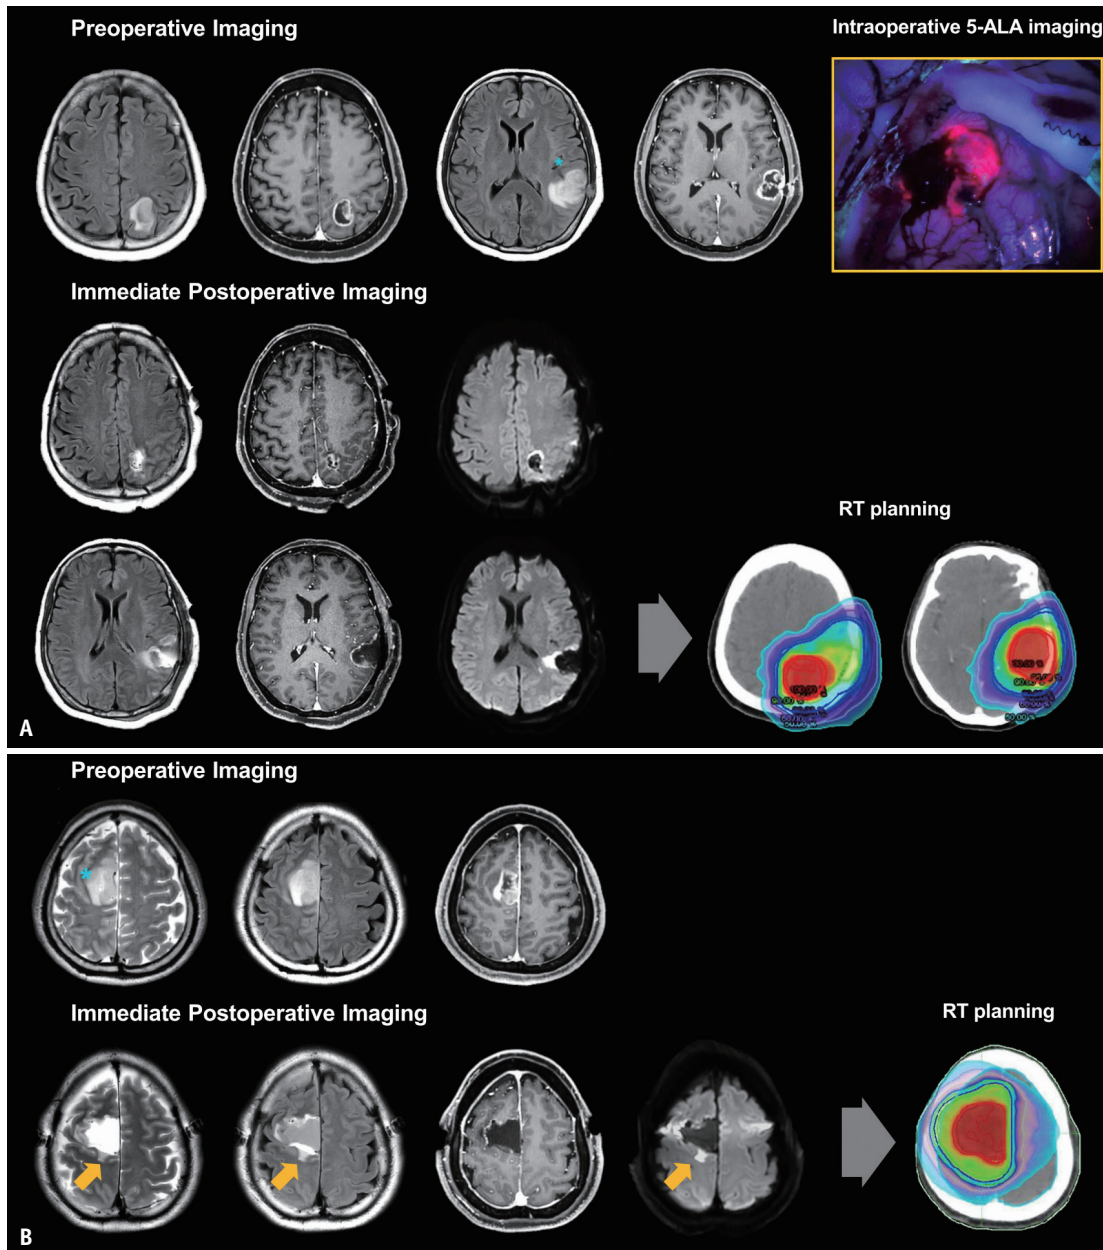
Representative cases of IDH-wildtype glioblastomas that have undergone supramaximal resection without residual contrast-enhancing or non-enhancing tumor. A: A 59-year-old female showed multicentric distribution of tumors on left parietal and temporal lobes (non-enhancing tumor marked in asterisk). Multicentric tumors were both removed. On surgical note, there were strongly fluorescent tumor tissues with 5-ALA guidance, and there was no residual fluorescent tumor tissue after tumor removal, suggesting total removal of the high-grade tumor portion. The T2 hyperintensities on preoperative and immediate postoperative imaging indicate postoperative edema and acute infarction (on diffusion-weighted imaging at $b = 1000 \text{ s/mm}^2$). Note that the surgical note can provide additional information when interpreting immediate postoperative imaging. In supramaximal resection without residual contrast-enhancing or non-enhancing tumor, the GTV (red contour) includes the resection cavity in RT planning. In supramaximal resection without residual contrast-enhancing or non-enhancing tumor, the GTV includes the resection cavities in RT planning. The red contour demonstrates the radiation isodose line encompassing the high-dose PTV, delineated with an additional margin from the GTV. B: A 53-year-old male underwent total resection of contrast-enhancing tumor as well as non-enhancing tumor (asterisk). On immediate postoperative imaging, postoperative edema is noted around the operative margin, while there is a newly seen T2 high, diffusion-restricted lesion posterior to the surgical cavity indicating postoperative infarction (arrows). Imaging confounders of residual non-enhancing tumor, such as residual peritumoral edema and surgically induced edema as well as ischemia, should be carefully examined. The GTV in this patient also included the resection cavity in RT planning. The red contour demonstrates the radiation isodose line encompassing the high-dose PTV, delineated with an additional margin from the GTV. IDH = isocitrate dehydrogenase, 5-ALA = 5-aminolevulinic acid, T2 = T2-weighted, GTV = gross tumor volume, RT = radiation therapy, PTV = planning target volume
